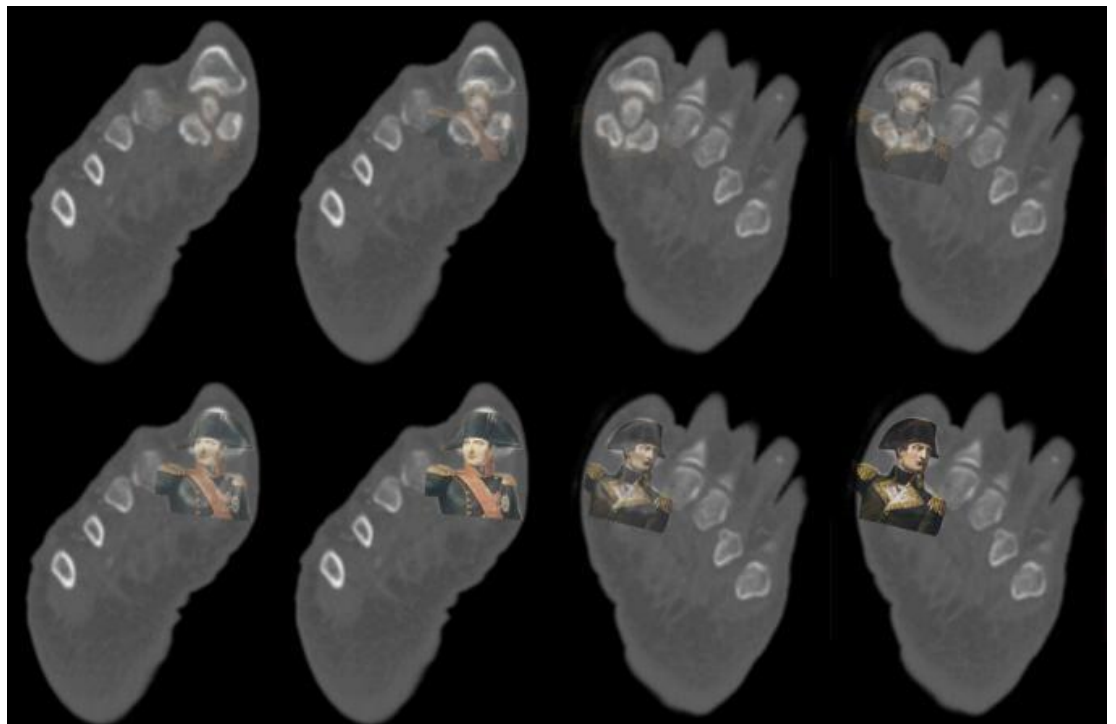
Image of the right and left feet by cross-sectional computed tomography with superimposition of Napoleon Bonapart's image at different levels of transparency.
